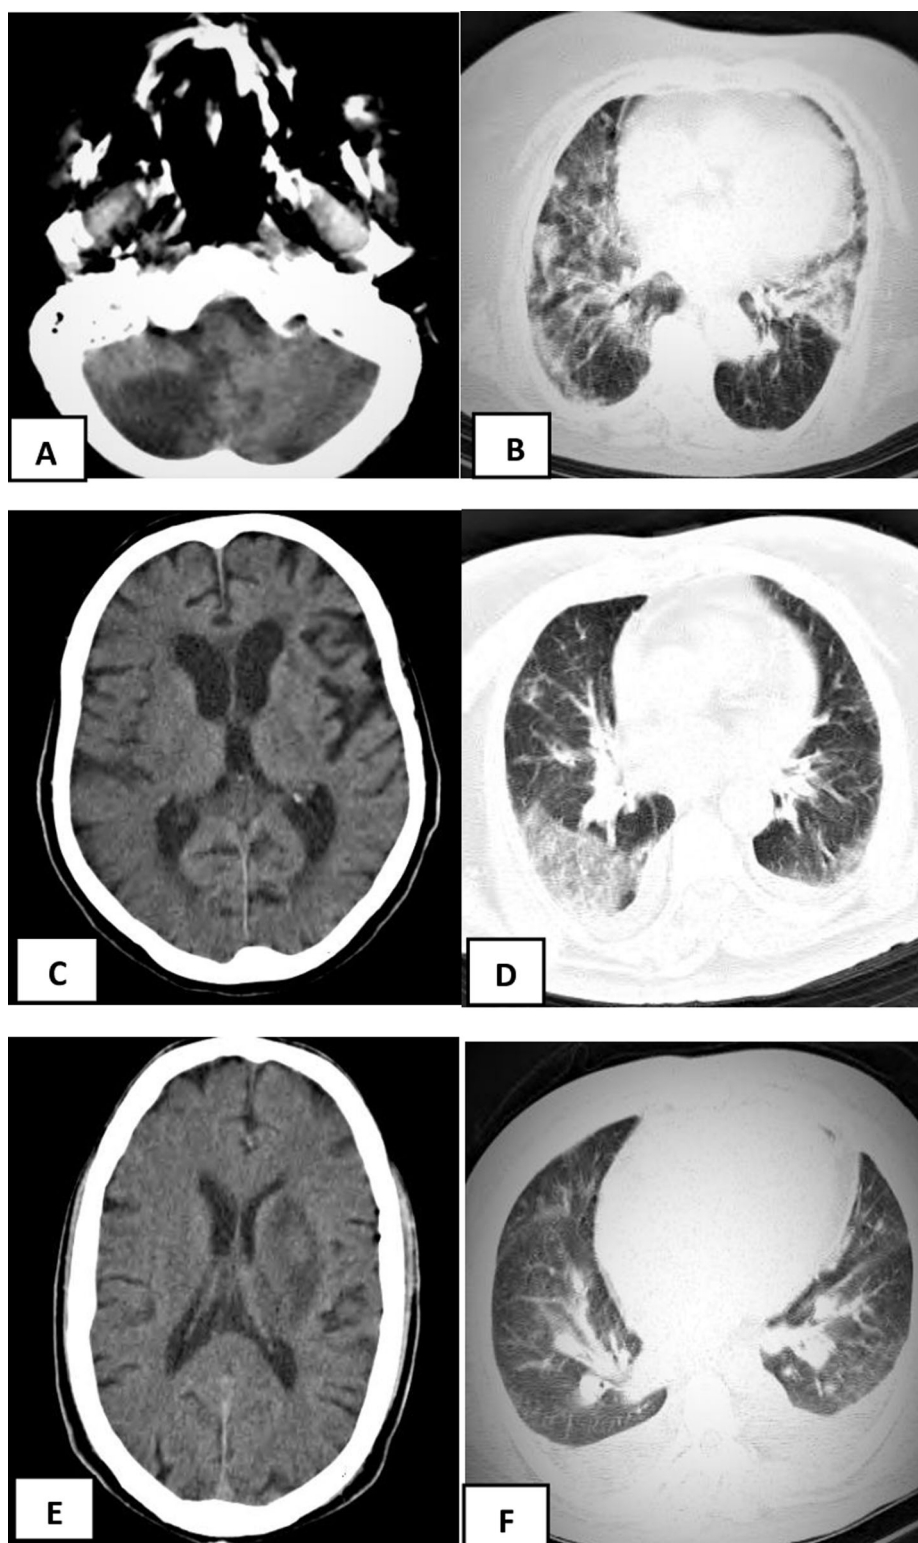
Brain and Lung CT scan of three patients. Imaging of Patient 1 shows low-density at right cerebellar (A); grand glass opacity at bilateral lung (B); Patient 2 shows attenuation at right hemisphere (C); grand grass opacity at the right lower lobe and bilateral pleural effusion (D); patient 3 shows low-density at left basal ganglion (E); pleural effusion and peripheral grand glass opacity bilaterally (F).
